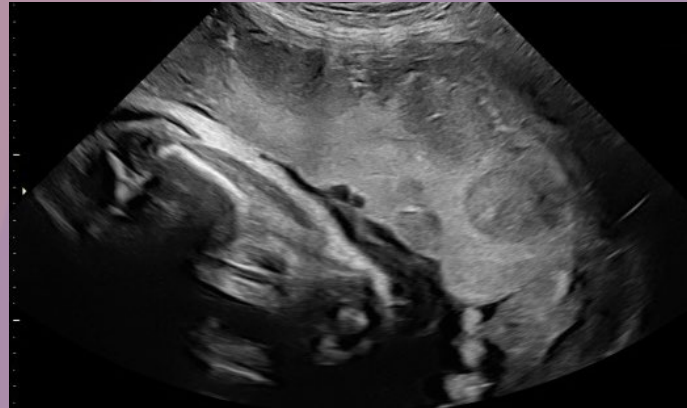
Liver metastases identified on KG's obstetric growth and wellbeing ultrasound
